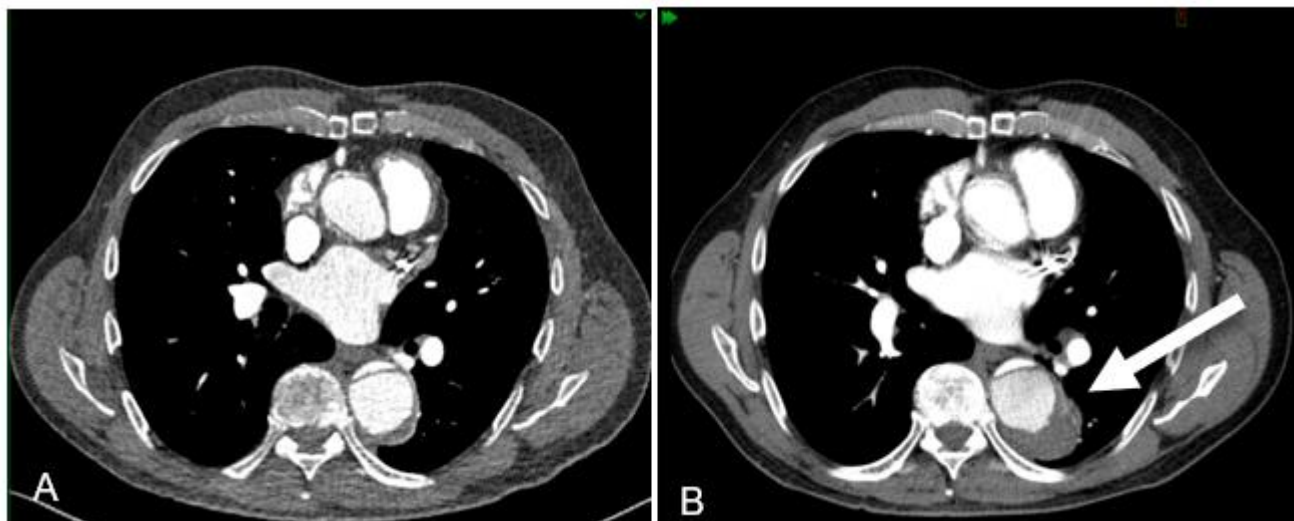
CTA of the chest from two months prior to admission shows the patient's chronic type B dissection (A). CTA of the chest on admission reveals the new ABPF with a periaortic hematoma and adjacent inflammatory changes (B).
